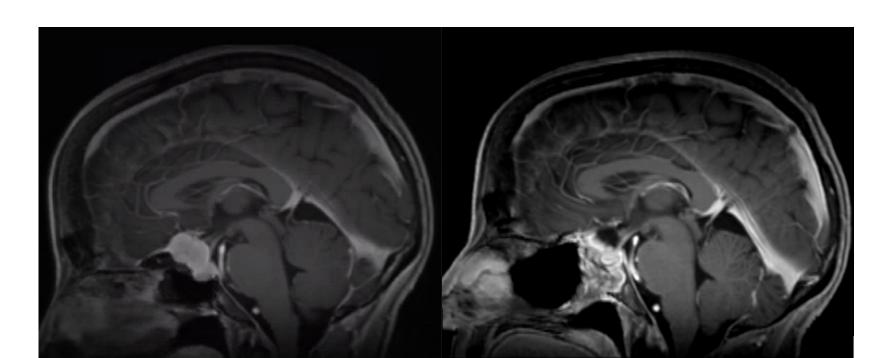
a) Pre-operative MRI demonstrating large tuberculum meningioma. b) Post-operative MRI demonstrating gross total resection.
